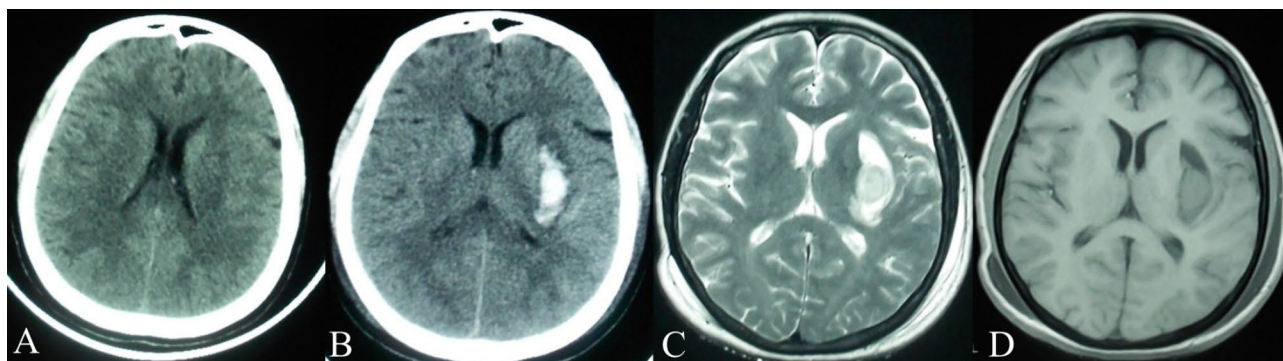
The right temporal lobe-shaped low-density focus (A) on the first postoperative head CT; The second CT and MRI (B–D) showed hemorrhagic cerebral infarction in left basal ganglia
